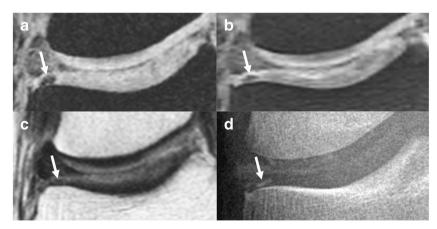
a-d Lateral knee joint of a 44-year-old man with single focal hyaline cartilage chondrocalcinosis at the medial tibia. (a) Coronal 3D T1-weighted gradient-echo sequence, (b) coronal reformation of 3D DESS, and a (c) coronal proton density-weighted FSE image showing a
